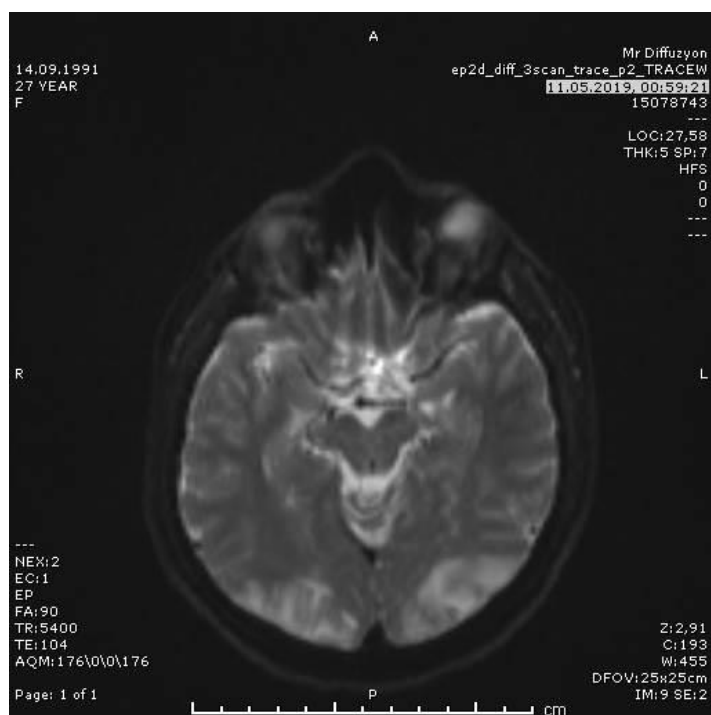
Hyperintense lesions on diffusion-weighted MRI
